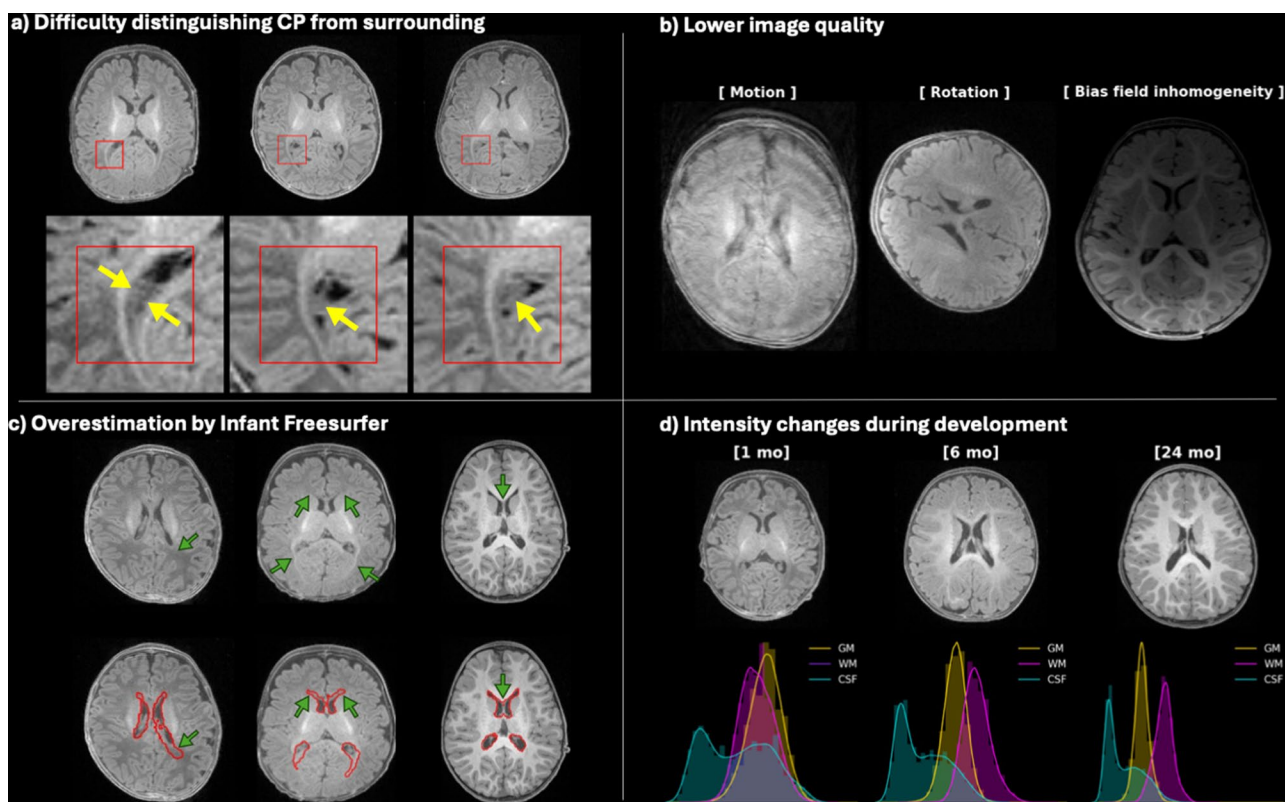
Common challenges in LV and CP segmentation for infant brain MRI. (a) demonstrates the difficulty of distinguishing the CP from surrounding structures (yellow arrows indicate the CP). (b) presents representative examples of lower image quality in infant scans, which impacts segmentation accuracy due to reliance on image quality. (c) shows that the LV label generated by InfantFS frequently produces false positives (green arrows). (d) shows the challenges in segmenting brain tissues due to variations in tissue contrasts as the infant brain develops
